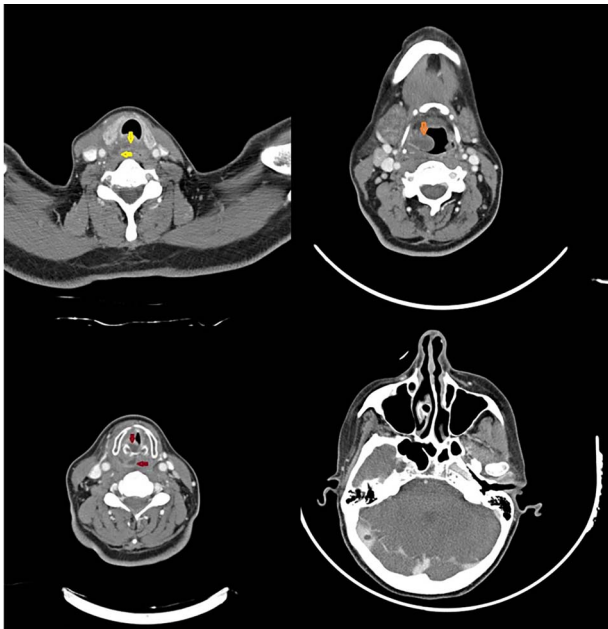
Axial contrast-enhanced CT scan of the neck depicts soft tissue swelling of the right side of the supraglottis, the glottis and the subglottis. Non-enhancing tissue in the posterior aspect of swollen subglottis is present surrounding the right side of the upper cricoid cartilage. An extension of non-enhancing tissue is seen in post-cricoid mucosa/hypopharynx and visceral space posterior to the trachea. The mentioned non-enhancing tissue could represent an abscess cavity or necrotic tissue. All paranasal sinuses are clear, and there is no peri-antral fat stranding.
